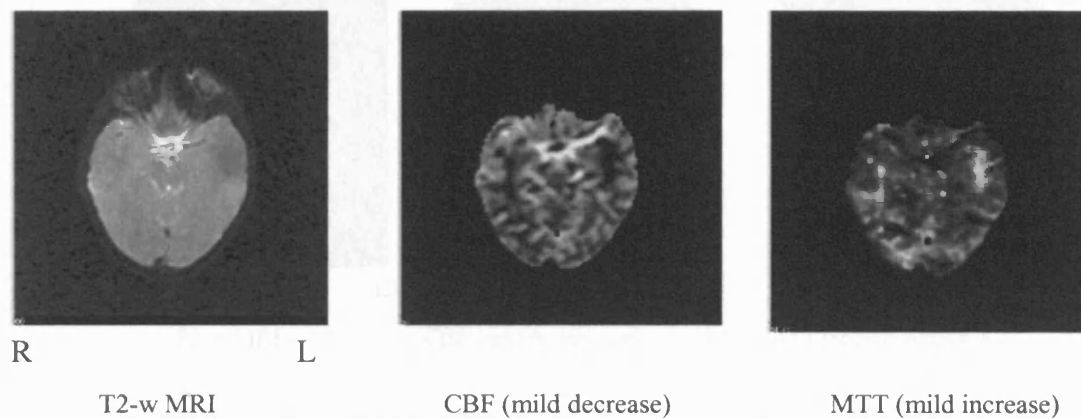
Perfusion MRI (DSC-MRI) in a patient with sickle cell anaemia and seizures. Normal T2-weighted MRI; mild decrease in cerebral blood flow (CBF) or (-), mild increase in the mean transit time (MTT) or (+) in the right temporal areas. Cerebral blood volume (CBV) maps are similar to CBF. R: right; L: left.
